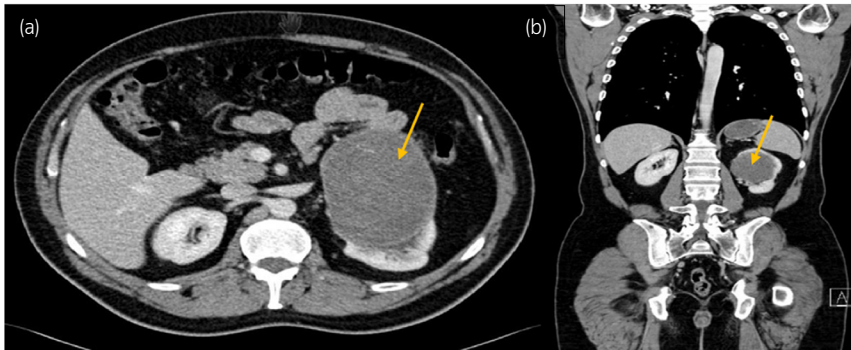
(a, b) Computed tomography scan revealed a large mass in the upper pole of the left kidney.
